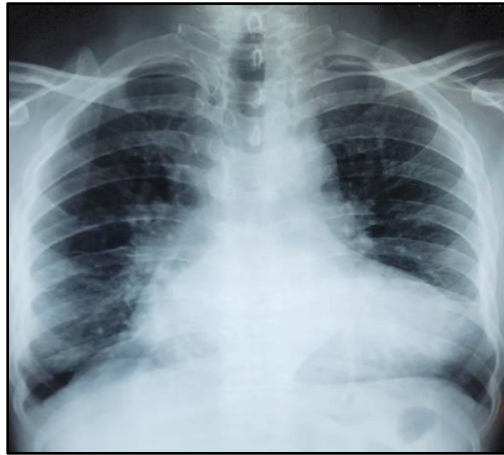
Chest X-ray showed cardiomegaly and increased pulmonary vasculature.
